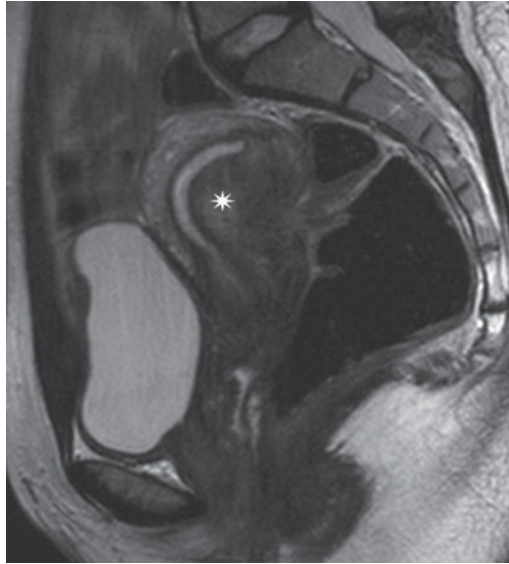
Magnetic resonance. Adenomyoma. Sagittal T2-weighted image. Retroverted uterus. A rounded lesion (*asterisk*) with ill-defined margins can be seen at the level of the posterior wall distorting the endometrial cavity
